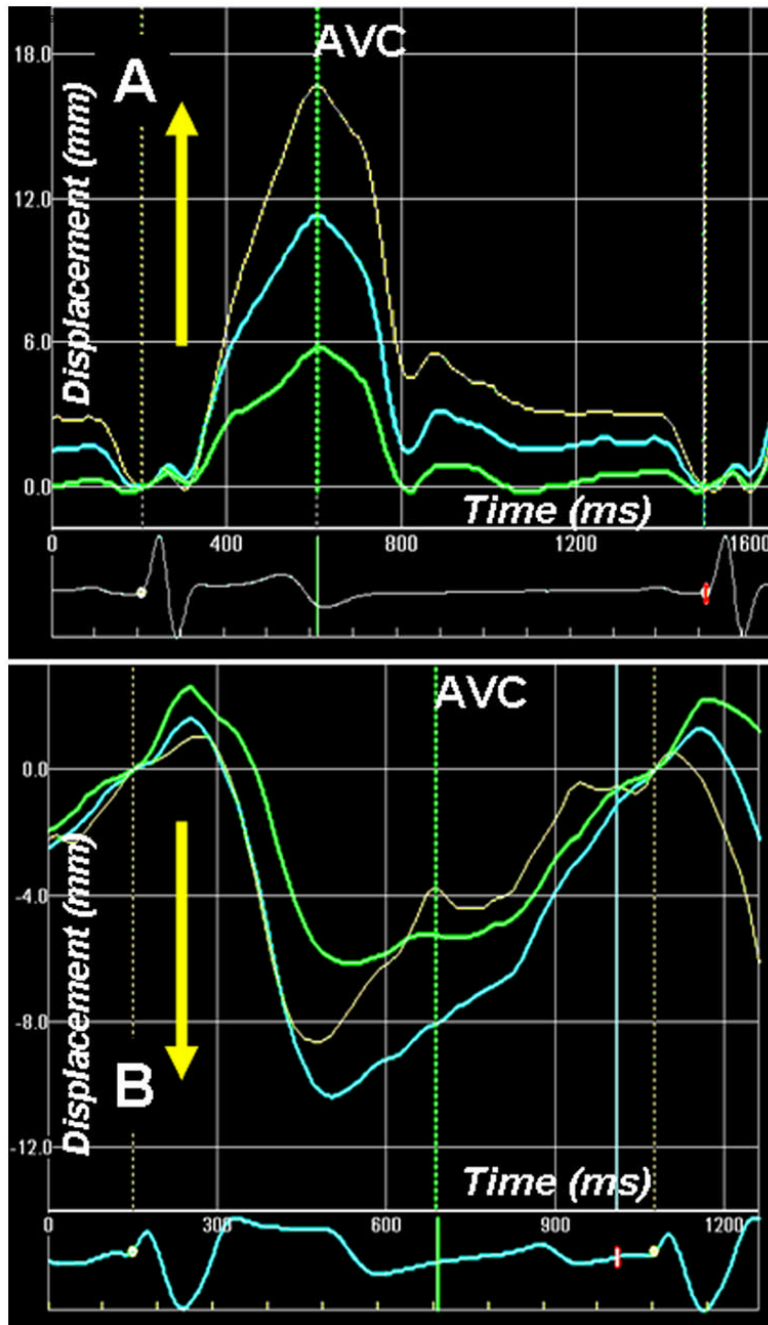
Apex-to-base longitudinal displacement of the left ventricle (LV) measured by 2-D speckle tracking of B-mode ultrasound images (2 D strain) in normal (A) and a patient with dilated cardiomyopathy (also shown in Figure 4). In normal healthy individual, the LV base descends towards the apex and there is base-to-apex gradient of longitudinal displacement. Note that the descent of the LV base towards the apex is associated with higher longitudinal shortening strains from the LV apex (Figure 4). The longitudinal strain gradient is reversed in patient with dilated cardiomyopathy (figure 4). This is associated with paradoxical longitudinal ascent of the LV base in systole. Phases 1–5 are described in Fig. 6 legend.
